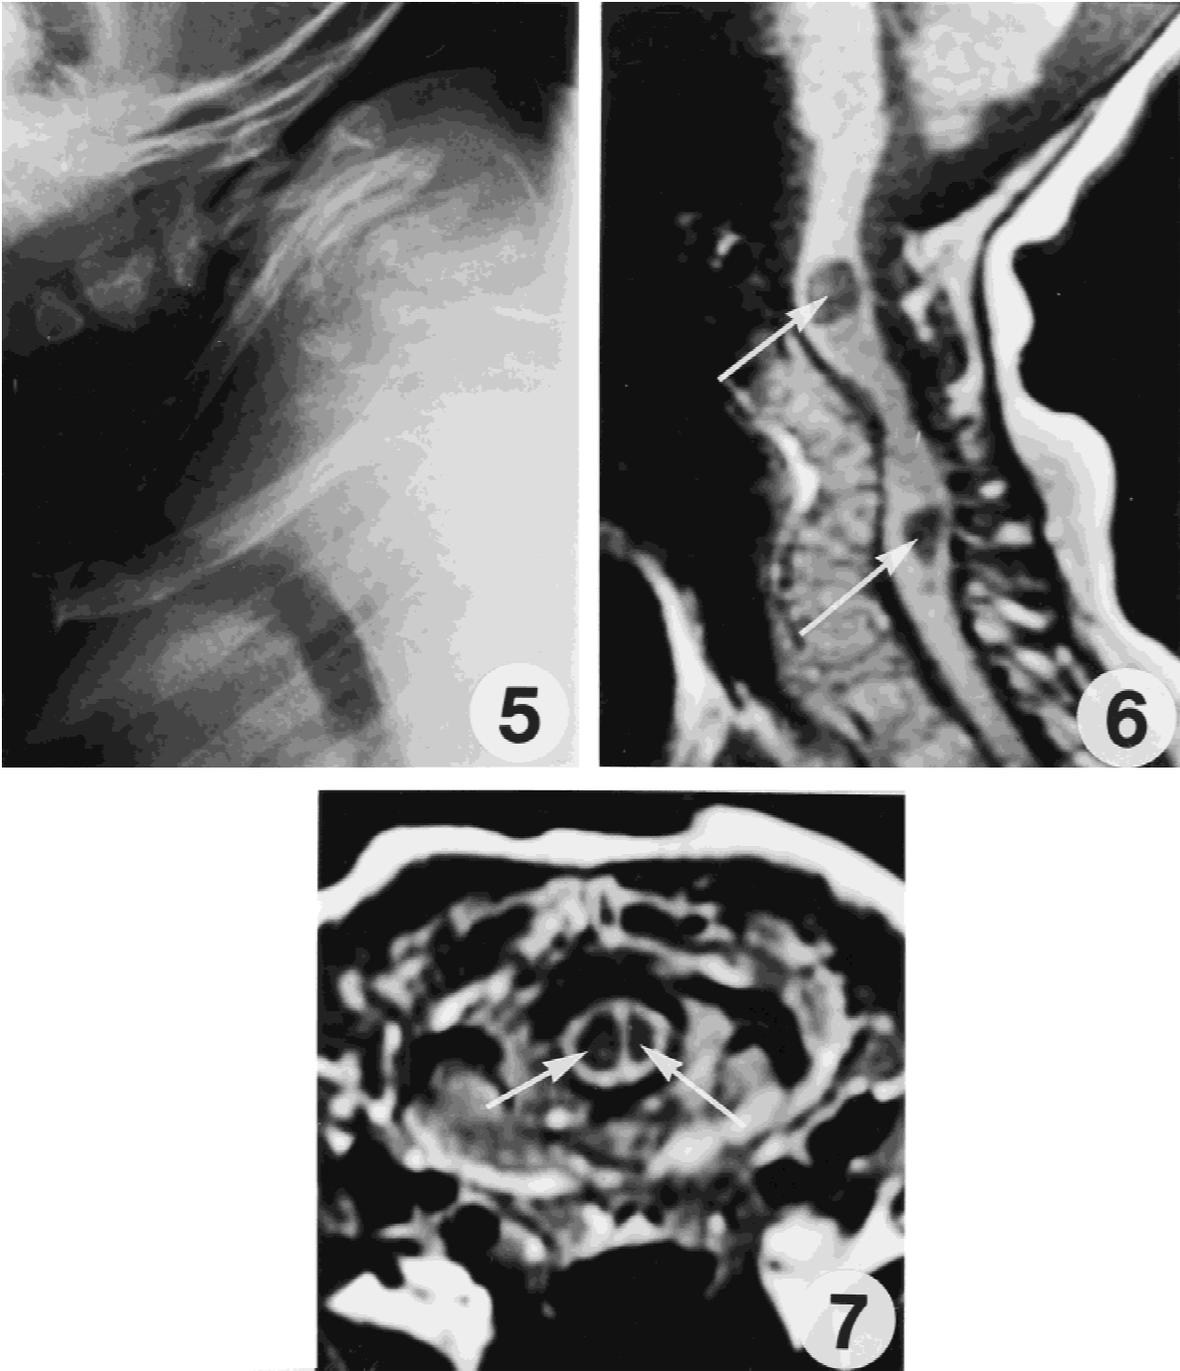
Lateral radiograph of patient at 20 months. There is marked angular kyphosis centered at the fourth cervical vertebra.
